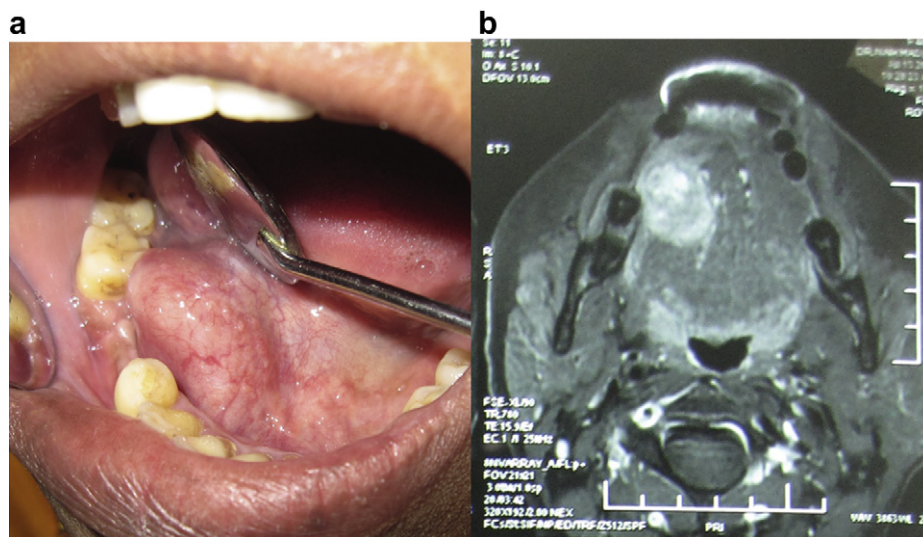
a: Tumor extension. b: MRI scan of the tumor.
